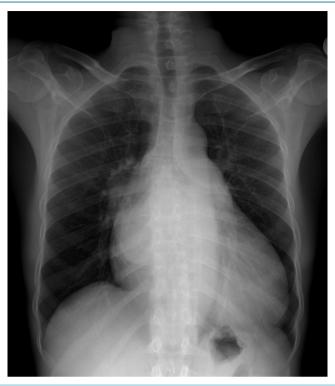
X-ray chest PA view showing LV (left ventricular) enlargement—a large convex left ventricle extending below the left hemidiaphragm and "double atrial shadow" of left atrial enlargement (double density sign) seen in right atrial border.
